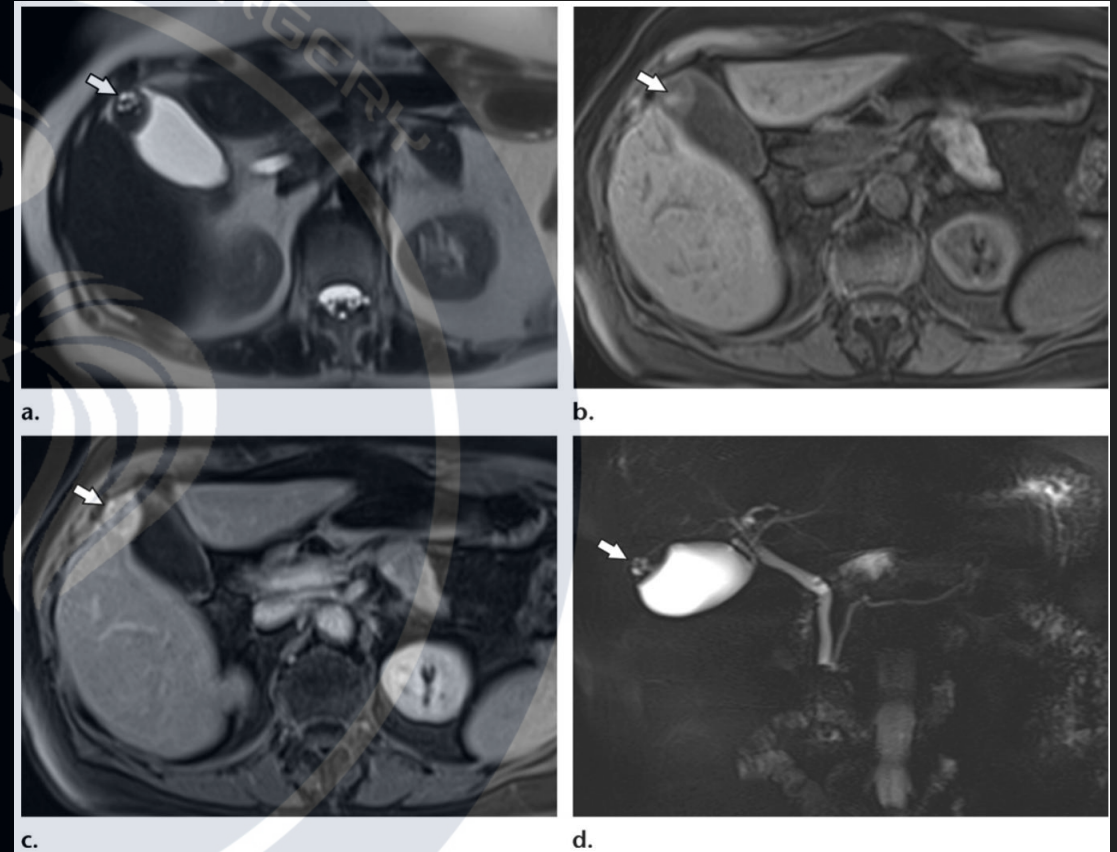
Gallbladder adenomyoma mimicking gallbladder cancer in a 53-year-old woman. (a) Axial T2-weighted image shows a focal mass (arrow) in the fundus that is hypointense with areas of high signal intensity from dilated Rokitansky-Aschoff sinuses. (b) Axial fat-suppressed T1-weighted image shows that the mass (arrow) has a focus of higher signal intensity. (c) Axial contrast-enhanced fat-suppressed T1-weighted image shows that the mass (arrow) has fairly homogeneous enhancement, from hypervascular focal fundal adenomyomatosis mimicking gallbladder cancer. (d) Image from MR cholangiopancreatography shows the characteristic outpouchings from dilated Rokitansky-Aschoff sinuses (arrow), which distinguish the lesion from cancer.
